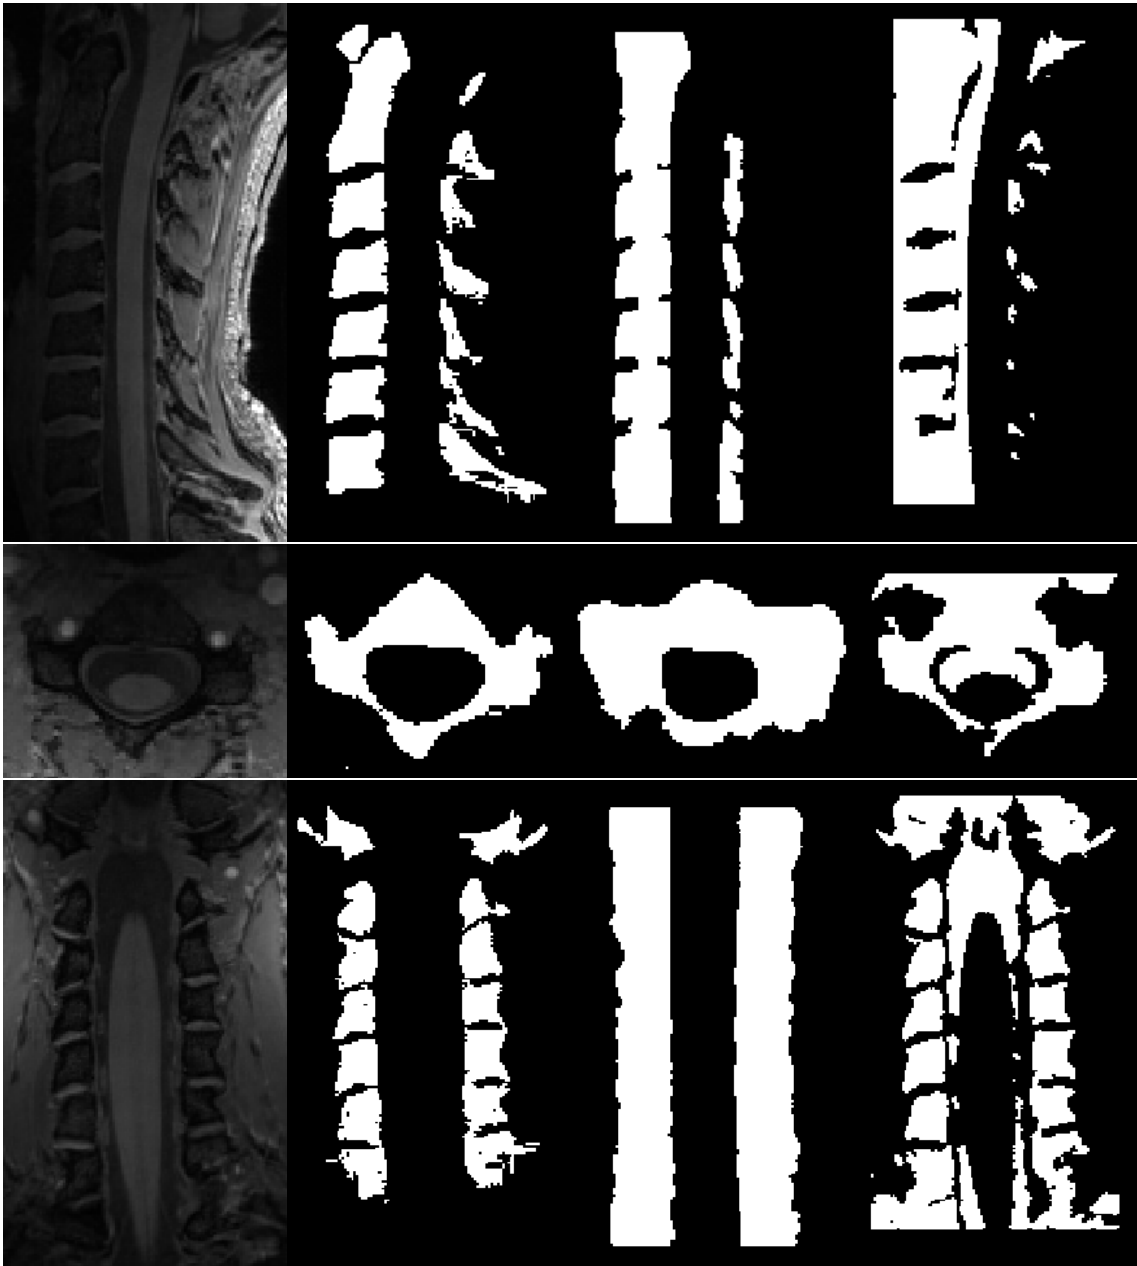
Comparison of the segmentations from the third subject. From left to right: a) MRI, b) manual segmentation, c) semi-automatic segmentation, and d) automatic segmentation. Top to bottom, the sagittal plane, the transverse plane and the coronal plane.
